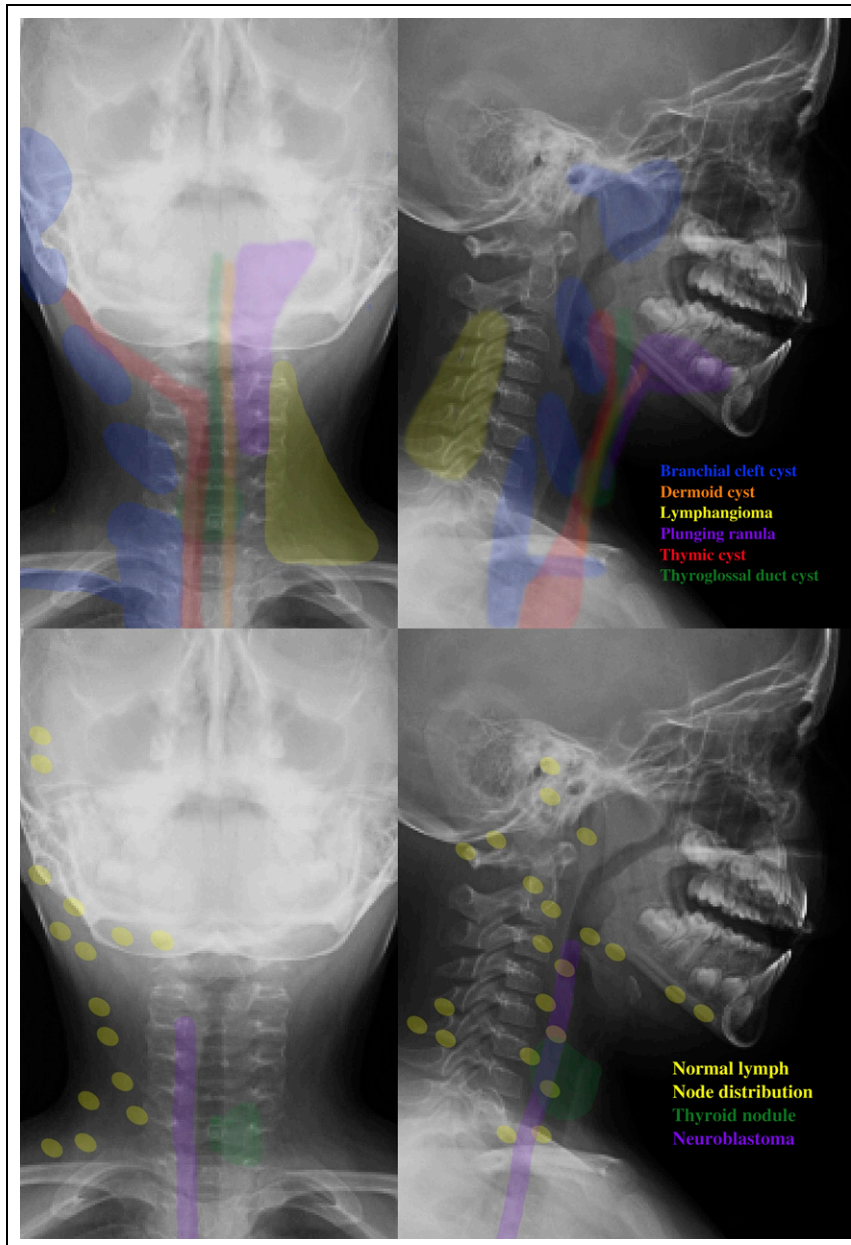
Classic anatomic locations of congenital lesions contrasted with classic anatomic locations of acquired lesions over radiographic image for anatomic orientation.
